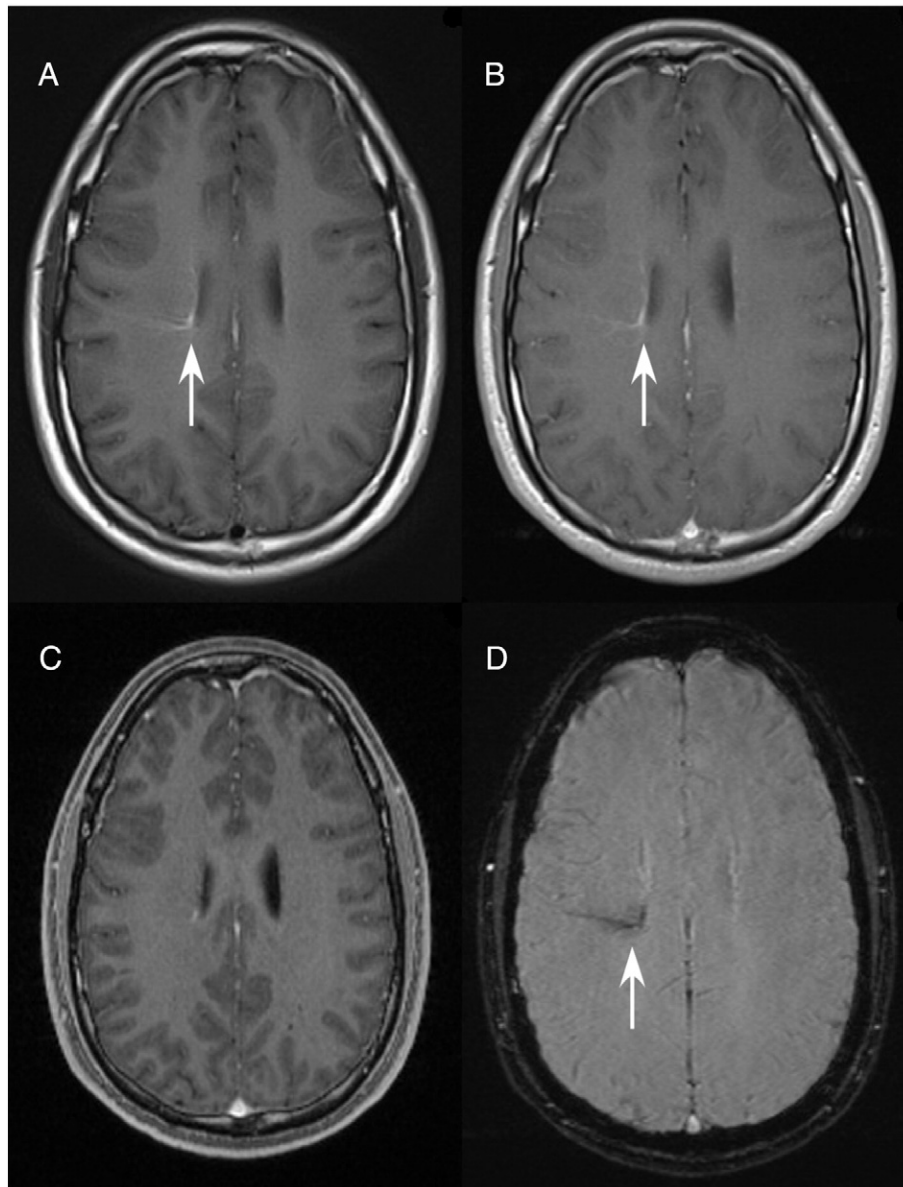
Sequences: T1W FLAIR BLADE (A), T1W SE (B), T1-MPR (C) and T2* (D). Compared to T1W SE conventional and T1-MPR, T1W FLAIR BLADE depicts better the arteriovenous malformations but equally well with the T2* sequence. The arrows show the AVM's.
